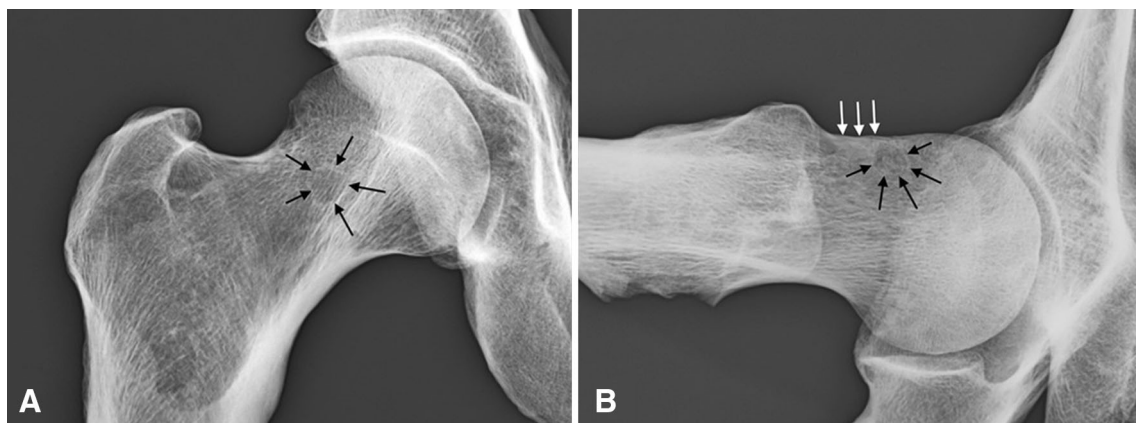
B (A) The AP radiograph of the hips reveals the presence of a herniation pit (arrows)—a fibrocystic degenerative lesion—at the aspherical portion. (B) The cross-table axial radiographs shows the herniation pit (black arrows) at the zone of asphericity and—as typically seen in cam-type FAI—an increase of the subcortical bone density (white arrows).
